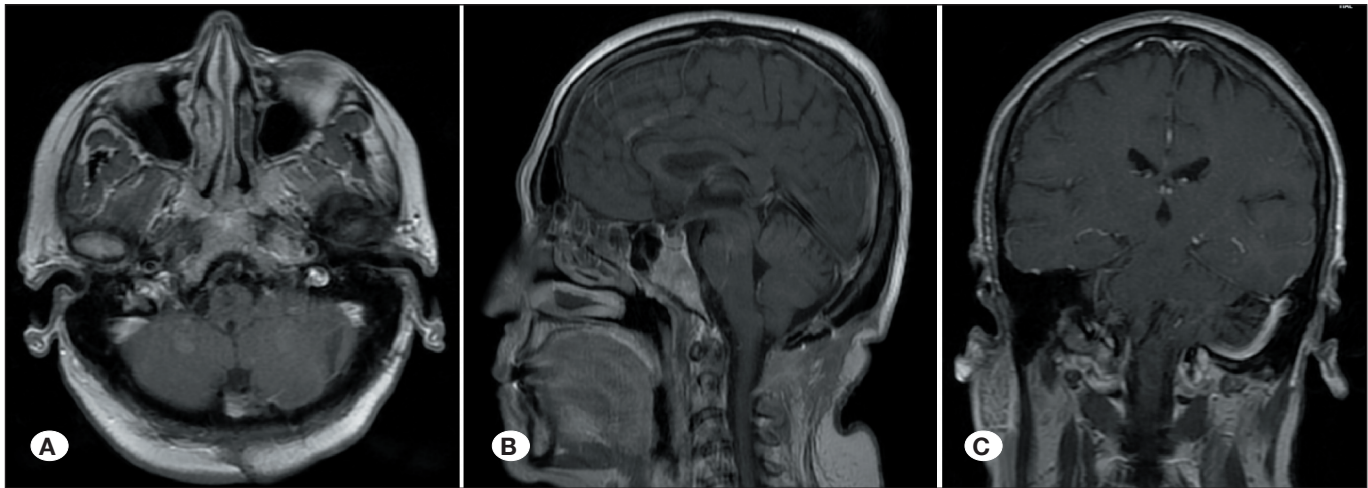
A six-month postoperative magnetic resonance imaging scans demonstrating gross total resection of the lesion, with no evidence of residual or recurrent tumor (A: axial, B: sagittal, C: coronal sections).
